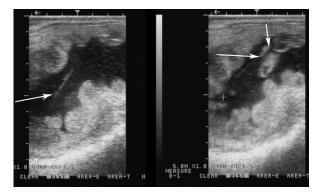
Ultrasonographic appearance of intraluminal adhesions after distention with fluid in a mare that was infused with commercial preparation of enrofloxacine (Baytril ®).
